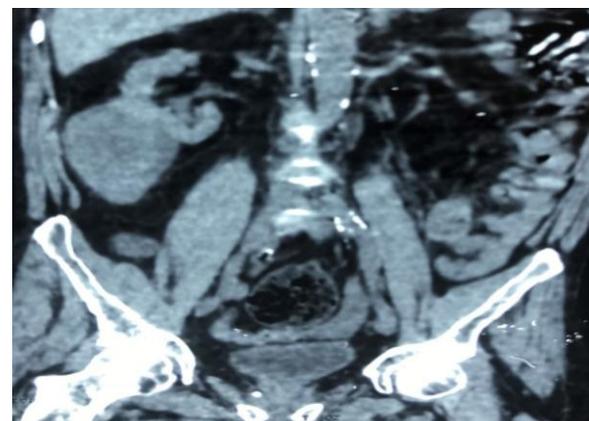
CT scan without injection: inferior polar renal tumor mass of mixed density measuring 9x6cm without loco regional invasion.
